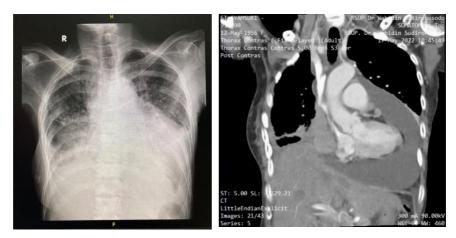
The results of the chest X-ray (left) and chest MSCT (right) from the patient.
